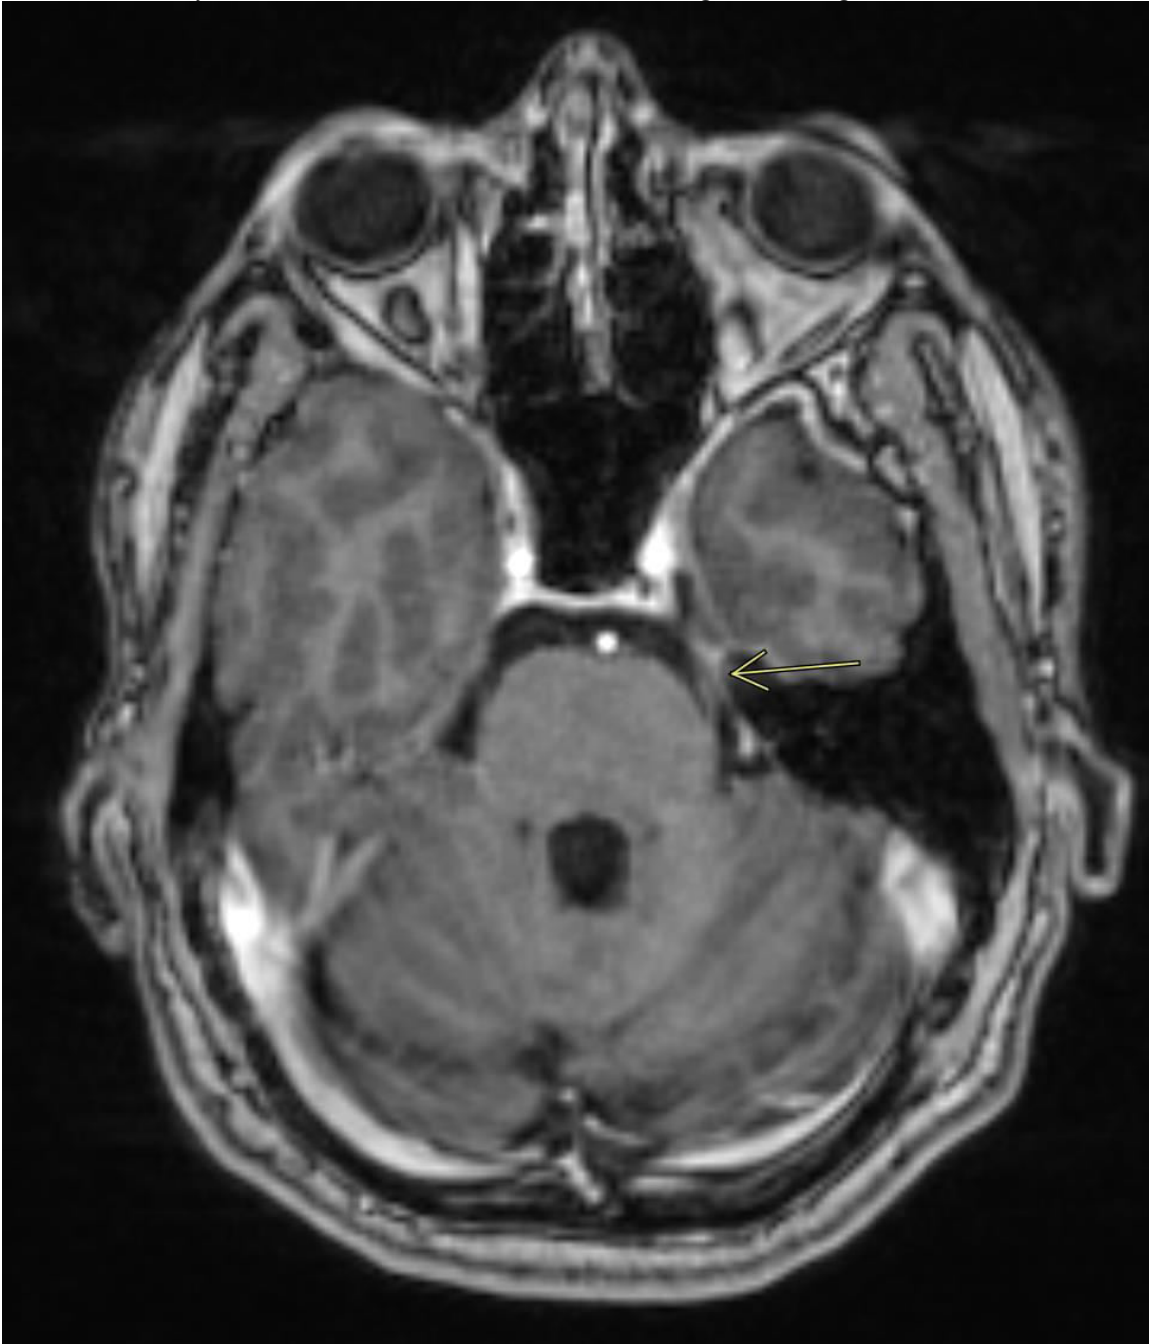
Brain MRI with IV contrast showed a thickened left trigeminal nerve at the initial presentation
